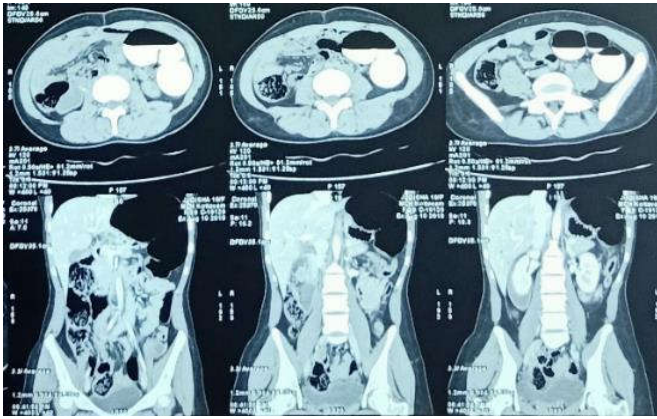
Coronal views of the closed loop obstruction picture on CT scan
